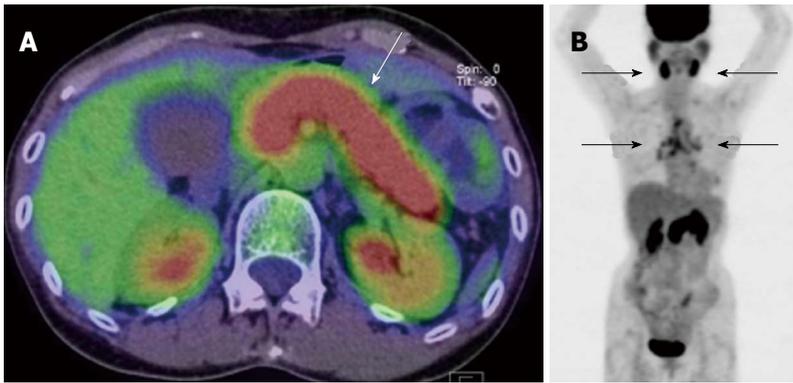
IgG4 related pancreatitis. A: PET/CT shows strong fluorodeoxyglucose (FDG) accumulation in the whole pancreas with swelling (arrow); B: MIP image of PET. Besides diffuse uptake in the pancreas, symmetrical FDG deposits were noted in the bilateral salivary glands and hilar, mediastinal lymph nodes (arrows). Distribution in the involved organs is characteristic of this disease.
